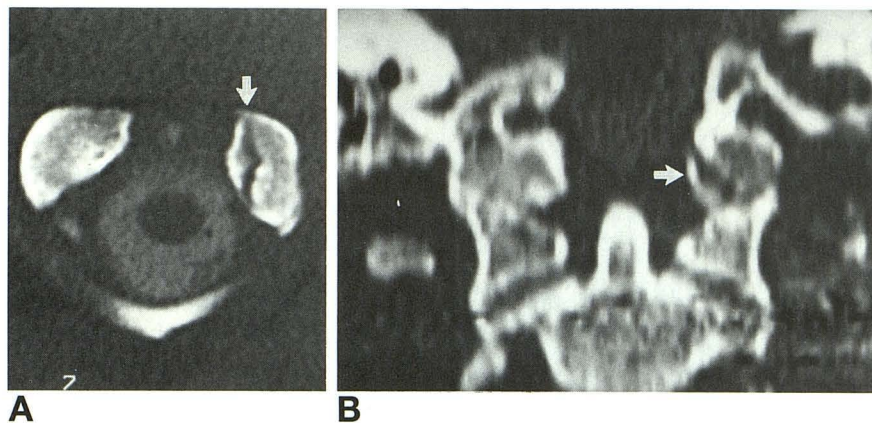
A, Axial CT image through the upper craniocervical junction demonstrating a fracture (arrow) on the left.
